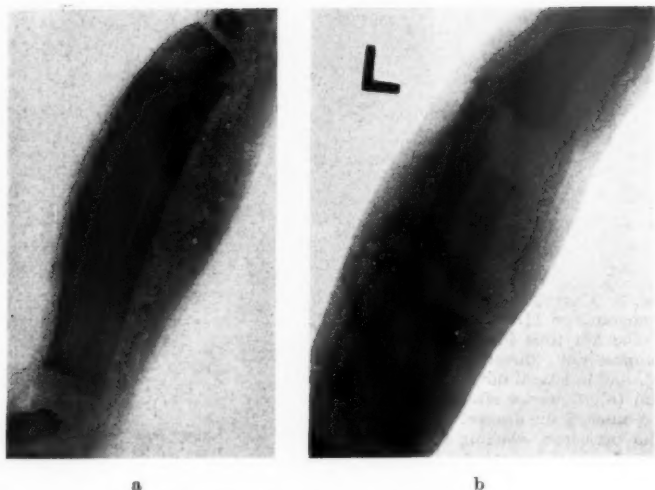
Case II. Roentgenogram on 5/29/1946, about 3 weeks after the onset of the disease. Extreme periosteal reaction along right tibia (5 a), left radius, ulna and humerus (5 b). The tibiae are curved forward.
